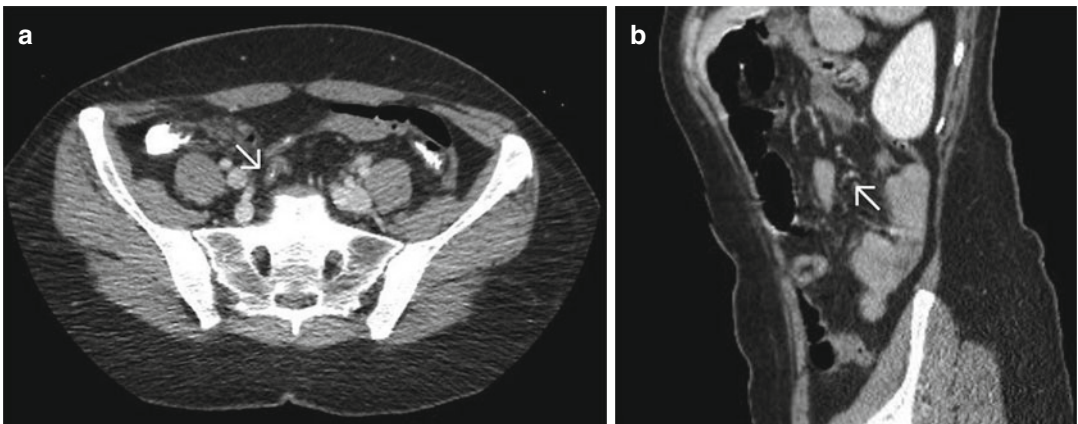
A contrast-filled Meckel’s diverticulum (white arrows) incidentally found on a CT scan in a 50-year-old woman, who was given positive oral contrast. Axial (a) and sagittal (b) view
